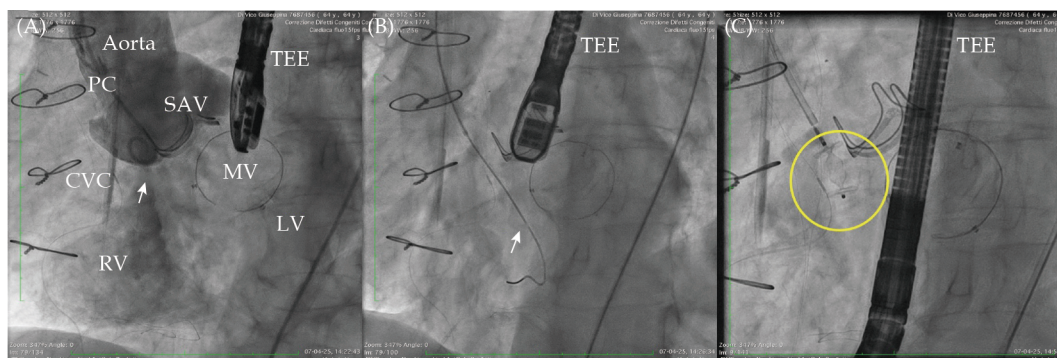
Fluoroscopic images of the procedure. (A) PC positioned at the level of the SAV to perform an aortography which depicts the fistula (white arrow) with passage of contrast media from the aorta to the RV; (B) retrograde crossing with a multipurpose catheter and a Stortz guidewire (white arrow); and (C) an Amplatzer Vascular Plug II device was deployed to ensure adequate sealing. CVC: central venous catheter; LV: left ventricle; MV: mitral valve ring; PC: pigtail catheter; RV: right ventricle; SAV: surgical aortic valve; TEE: transesophageal echocardiography.
